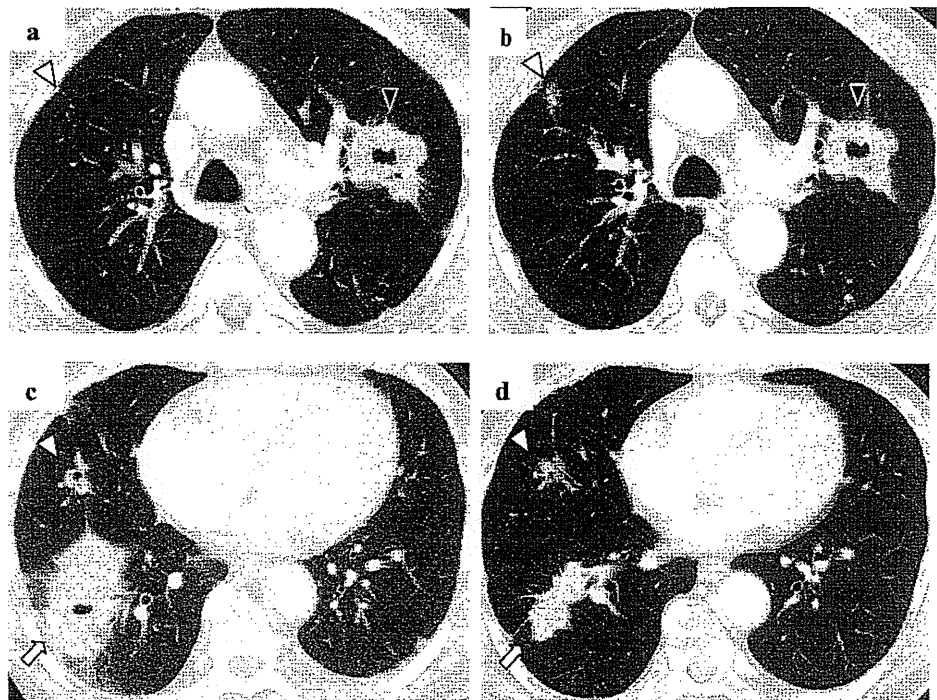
a, c Chest computed tomography before initiation of cetuximab combination therapy. b, d Two months after therapy. *Arrow* indicates a responding tumor; *black arrowhead* indicates a slightly responding tumor; *white arrowhead* indicates slightly enlarging nodules
